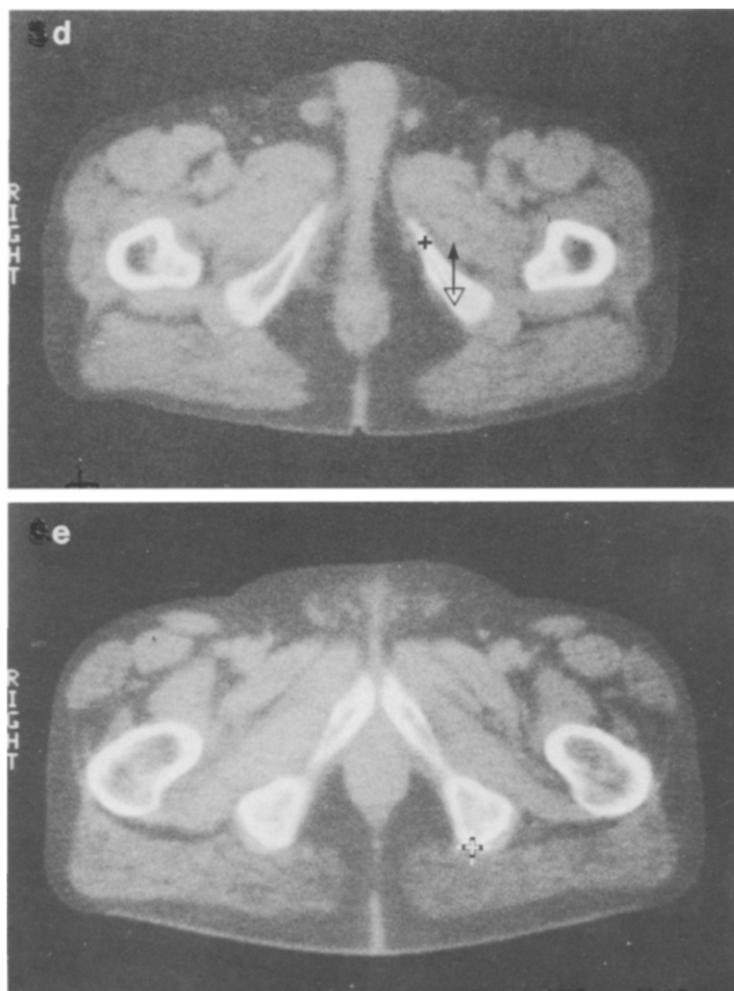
Transverse CT scans at different levels. Determined coordinates are indicated with crosses. (a) Midpoint of gluteus maximus origin (A-level in Fig. 3). (b) Midpoint of gluteus maximus femoral insertion (B-level in Fig. 3), GMa is gluteus maximus muscle belly. (c) Midpoint of gluteus maximus muscle belly (C-level in Fig. 3).
